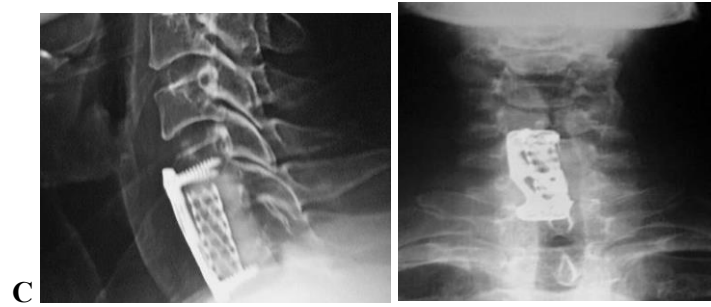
[A]: preoperative x-rays anteroposterior and lateral views, C6-7 segment level affected , [B]: T1 and T2 MRI sequences showing C6-7 CSD with abscess formation (red arrow) severely encroaching the spinal cord, [C] : Final follow up x-rays anteroposterior and lateral views after C6 complete corpectomy and partial C7 corpectomy and plate applied from C5 to C7.
